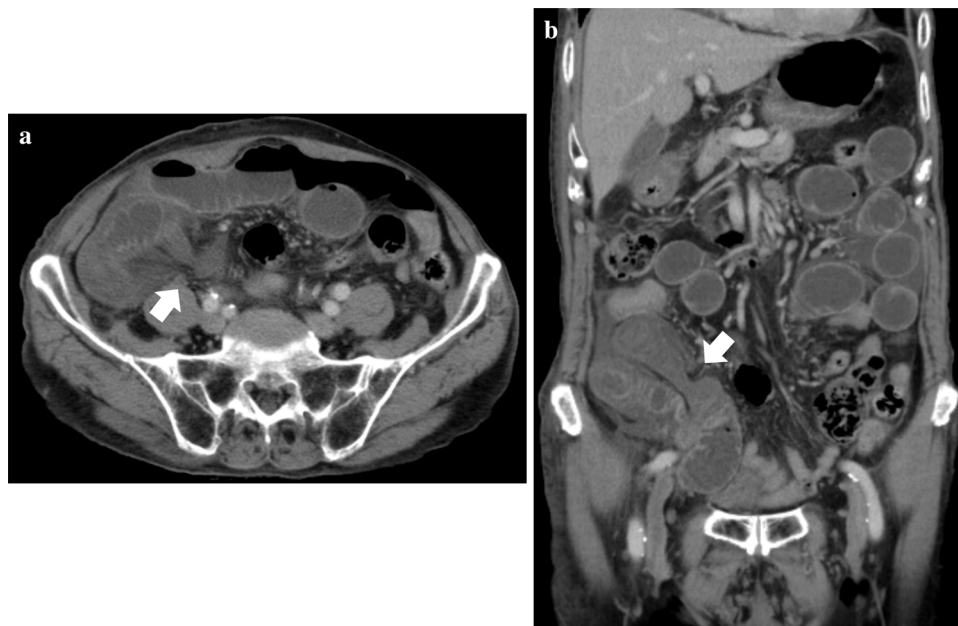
Computed tomography image showing dilation of the small bowel. The arrow indicates that a small intestinal caliber change is present behind the cecum (a: horizontal image, b: coronal image).
